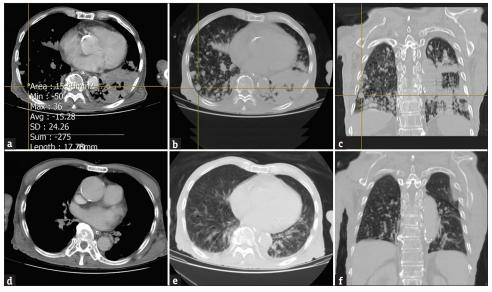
Chest computed tomography before and 3 months after tracheostomy. A chest computed tomography revealed left lower lung consolidation and numerous round nodules in the central and distal airways and even in the acini, especially at the dependent part (a-c). The nodule reflected a water attenuation with a density of -15.28 Hounsfield units and no definite enhancement after contrast administration (a). After tracheostomy for 3 months, all the lesions resolved completely with some peripheral airway bronchiectatic changes (d-f)
